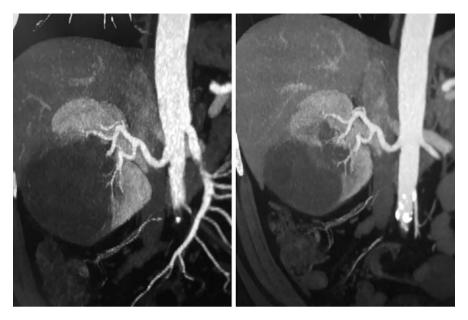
Coronal CT-scan Maximum Intensity Projection (MIP) reconstructions obtained during corticomedullary phase. The figure shows the relationship between the renal mass and arterial vascolature of the kidney. Main renal artery and segmental arteries are well visible
